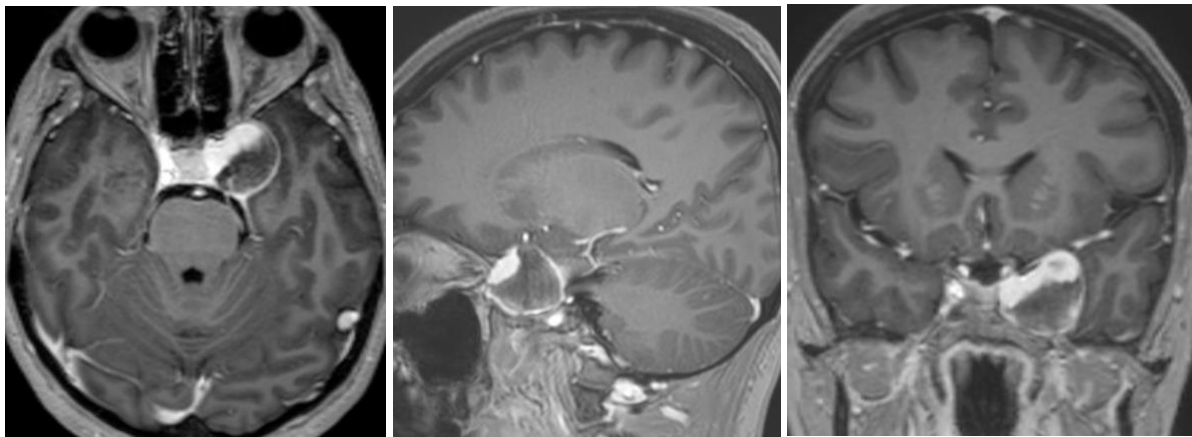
Pre-treatment MRI confirming a giant, partially thrombosed cavernous segment ICA aneurysm
